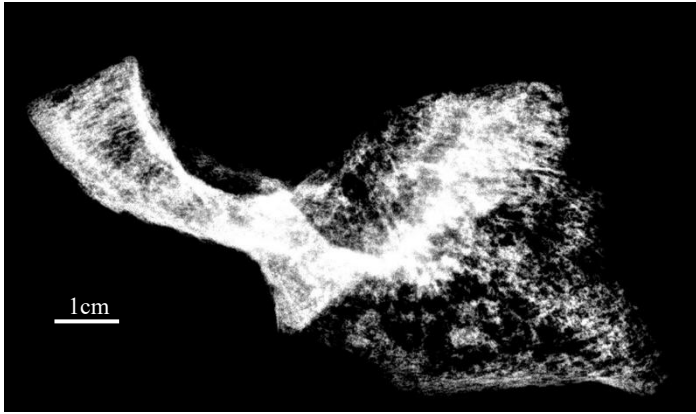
Radiograph of the calcaneonavicular fusion in SEP 42. Density differences are considered likely due to taphonomic alterations. Collège Claude Monet, Magny-en-Vexin, excavation of 1998.
